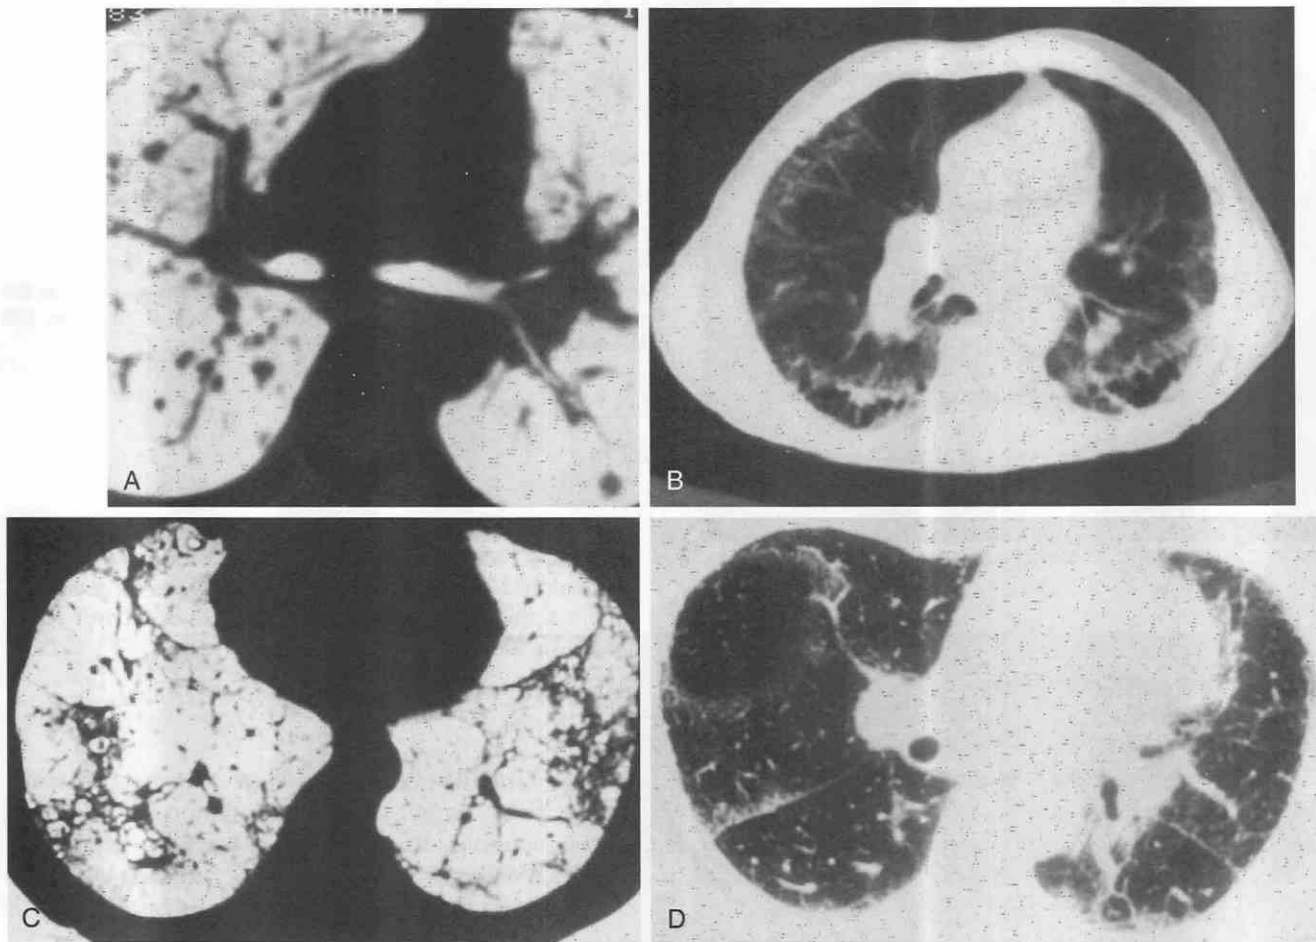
CT features of interstitial disease. A, Small interstitial nodules in a patient with sarcoidosis. Reticulation (B) and thickening of the pulmonary septa (C) in two patients with idiopathic pulmonary fibrosis. D, Irregular and shaggy interfaces between the lung and the fissures, pleural surfaces, and mediastinum are CT features characteristic of interstitial disease. Idiopathic pulmonary fibrosis. (A, B, and D, From Kuhlman JE: CT of diffuse lung disease. *Appl Radiol* 20:17-21, 1991.)
